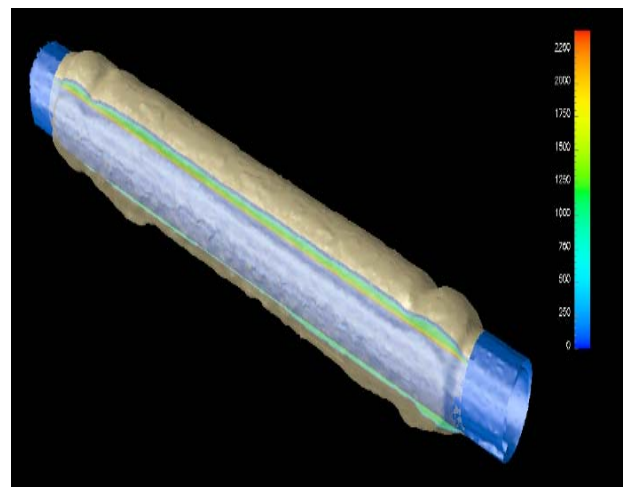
3D RENDERING OF A TISSUE-ENGINEERED BLOOD VESSEL [13] OBTAINED BY COMPUTED TOMOGRAPHY. THE TISSUE LAYER (INDICATED IN AN OFF-YELLOW COLOR) IS GROWN ON A STEEL MANDREL (BLUE) WITH 4 MM OUTER DIAMETER. THE TISSUE COMPLETELY ENCLOSES THE MANDREL, BUT THE TISSUE WAS CLIPPED IN THIS IMAGE TO SHOW THE CROSS-SECTIONAL INTENSITY DISTRIBUTION AND THE THICKNESS IRREGULARITIES. THE FIXATION GROOVES SHOW PROMINENTLY AT EACH END OF THE TISSUE SECTION. NOTE THAT THE APPARENT TISSUE DENSITY INCREASE NEAR THE MANDREL IS AN ARTIFACT CAUSED BY PARTIAL-VOLUME EFFECTS.
